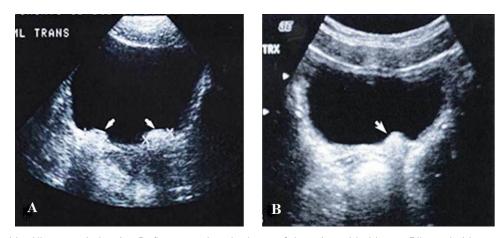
Bladder Ultrasound showing Deflux mound at the base of the urinary bladder. A: Bilateral sides, B: Unilateral left side.
